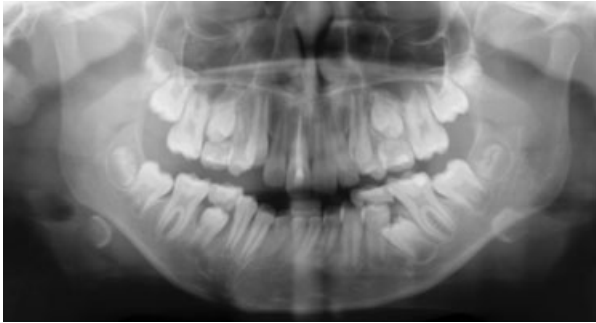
Orthopantomogram from a 10-year-old girl with reimplantation of right central incisor after traumatic avulsion.
